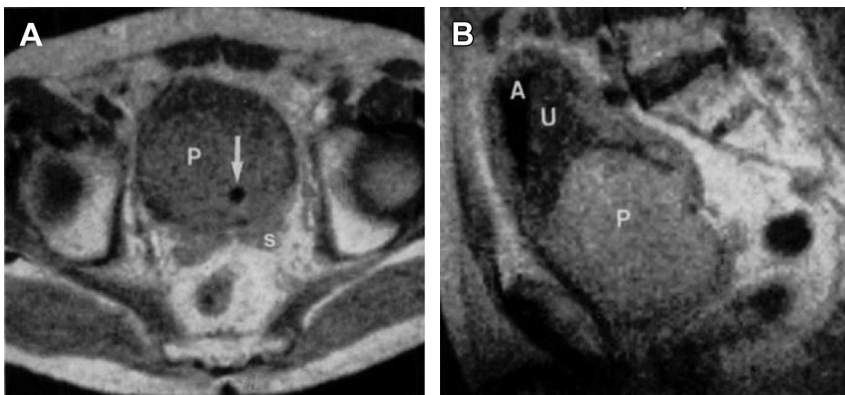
Prostate MRI c. 1983.⁵ These were among the first published MRI images, obtained with a 0.35-T coil. In the transverse scan (A), the prostate (P) is enlarged and the Foley catheter (arrow) in the prostatic urethra is displaced posteriorly to the left by adenomatous tissue. Seminal vesicles are seen inferior to the bladder (s). In the sagittal scan (B), air (A) and urine (U) level can be seen in the bladder. At the time, magnet strength was not capable of showing zonal anatomy or small cancers. (From Hricak H, Williams RD, Spring DB, et al. Anatomy and pathology of the male pelvis by magnetic resonance imaging. *AJR Am J Roentgenol* 1983;141(6):1107; with permission.)
